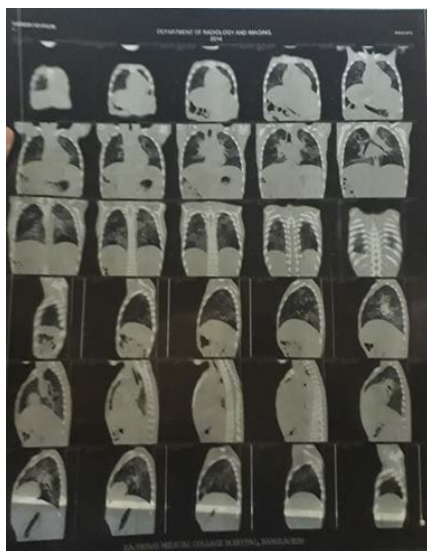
HRCT of chest showing homogeneous ground glass attenuation with reticulation and honeycombing in the both lung
